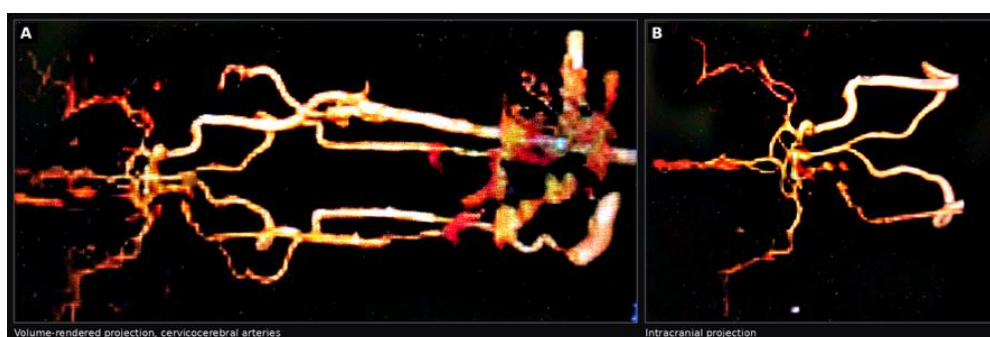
Three-dimensional volume-rendered reconstructions from the computed tomography angiogram of 7 September 2020. (A) Volume-rendered projection of the cervicocerebral arterial tree showing marked side-to-side asymmetry, with a sparse, faint and irregularly opacified carotid axis on one side contrasted against a densely opacified contralateral axis and its branch tree. (B) Intracranial projection in which the affected carotid axis and its distal branches are thin and poorly attenuating, whereas the contralateral carotid siphon and middle cerebral artery are broad and brightly opacified. On the axial source images the attenuated axis corresponded to the right common and internal carotid arteries. Both reconstructions are shown as acquired, without added arrows or labels, so that the asymmetry of opacification can be judged directly.
